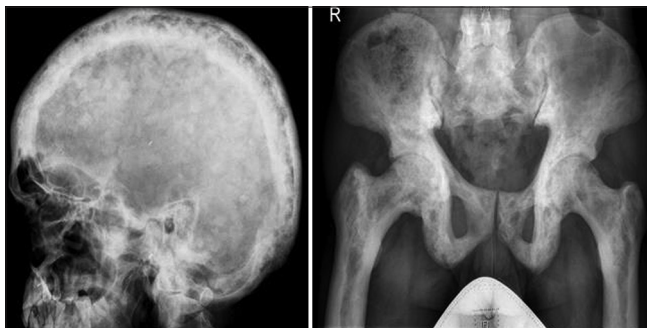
X-ray showing the sclerotic bony involvement of skull and pelvis in Paget's disease
